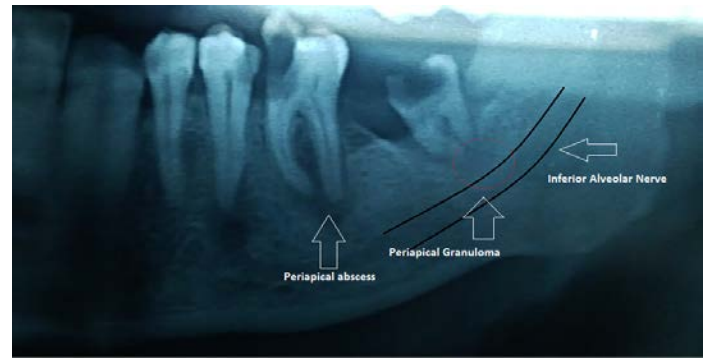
Periapical abscess under 1st Molar and Periapical granuloma under 3rd Molar
